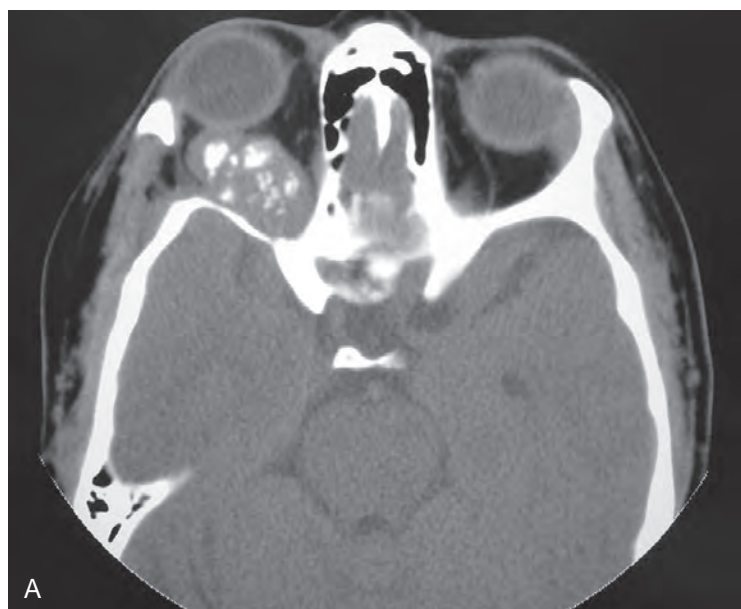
Contrast-enhanced computed tomography scan of a patient with a liposarcoma of the right orbit.
